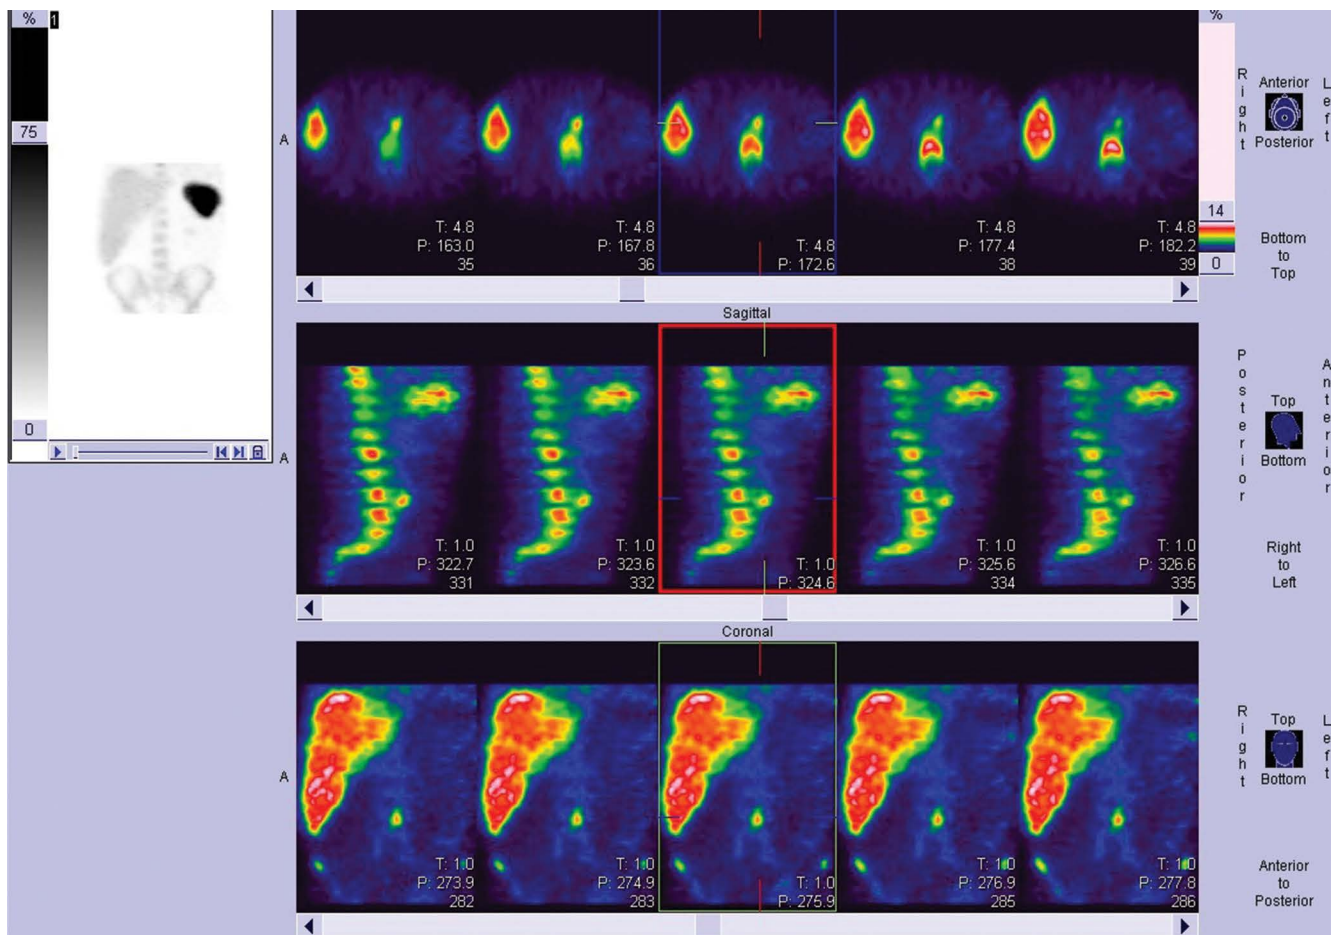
SPECT after 4 hours there was a small focus on the level of L4/L5 intervertebral space and slightly to the left of the midline of the body
